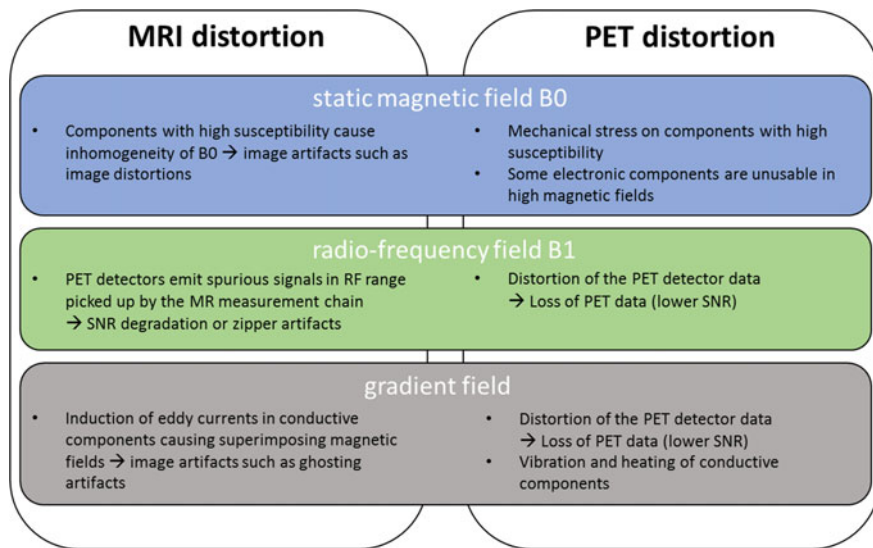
Mutual influences of simultaneous PET-MRI
